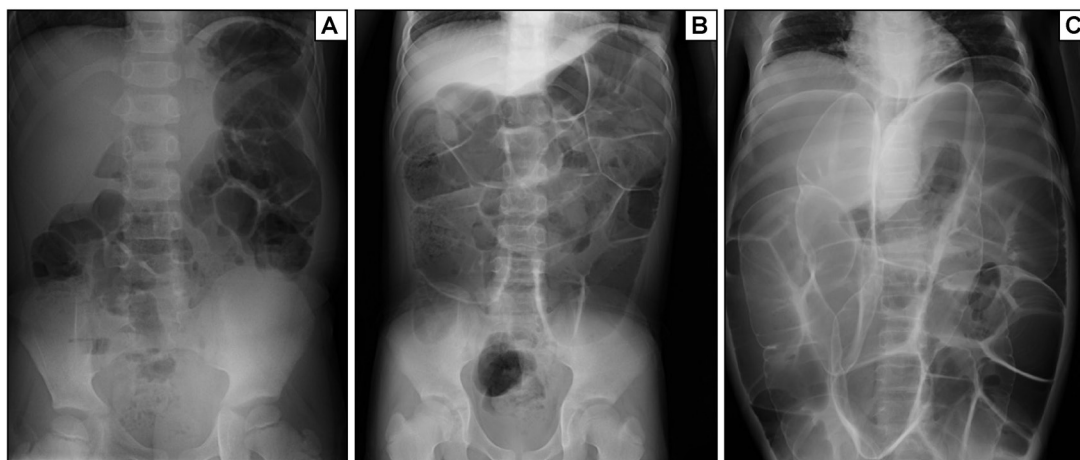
Abdominal X-rays of chronic idiopathic intestinal pseudo-obstruction. The patient remained asymptomatic until the age of 5 years. At 7 years of age, she experienced abdominal distention, which gradually worsened over time. By 11 years of age, her symptoms had become severe enough to necessitate ileostomy. Despite requiring home parenteral nutrition (HPN) due to the daily loss of 8000 mL of intestinal fluid through ileostomy, she has survived for >15 years postsurgery and continues to manage her daily life. (A) 5 years of age. (B) 7 years of age. (C) 11 years of age before ileostomy surgery. This X-ray image appears to show free air at first glance, but since there are no symptoms such as abdominal pain, it is considered to be observing a part of the intestinal gas.
